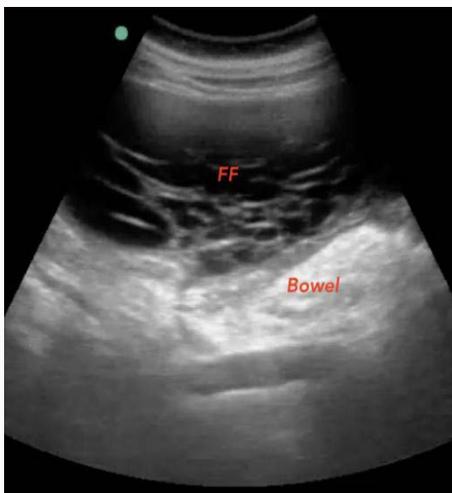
Transabdominal ultrasound of the left lower quadrant showing free fluid with lacelike internal echoes and bowel loops (FF: Free Fluid).
